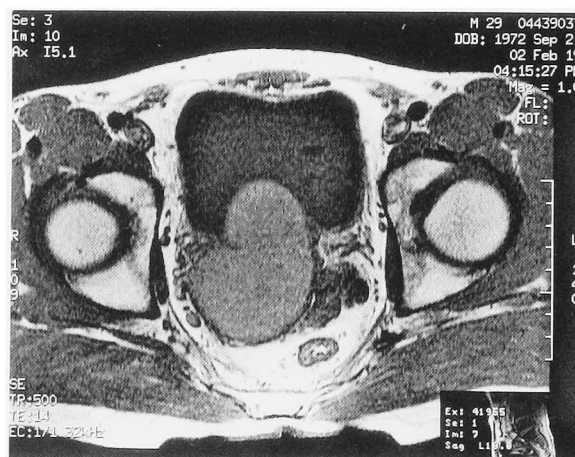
MR imaging of the pelvis showed a large mass with high T1-weighted signal intensity, which measured 8 cm in its greatest diameter, arising from the right seminal vesicle.
